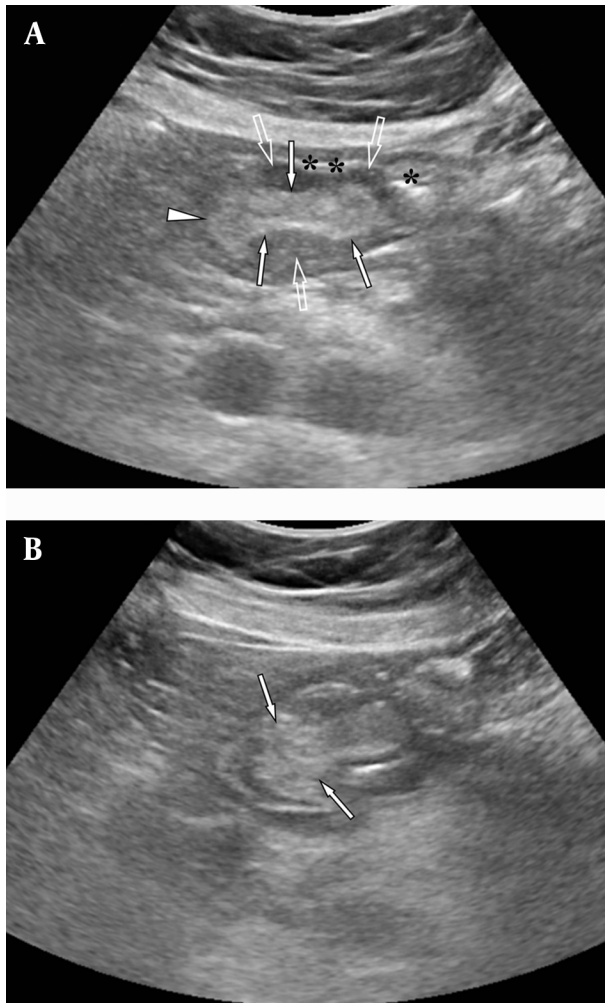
A 54-year-old woman with melena and severe anemia. A, Transverse gray-scale sonography of the epigastrium in the supine position shows a hyperechoic polypoid mass (arrows) in the gastric antrum lumen (asterisks), which is covered by thickened hypoechoic mucosa (open arrows) except for the right lateral side (arrowhead), suggesting denuded mucosa; B, On transverse gray-scale sonography of the epigastrium in the right lateral decubitus position, the mass (arrows) prolapsed toward the duodenum, indicating a pedunculated morphology.
